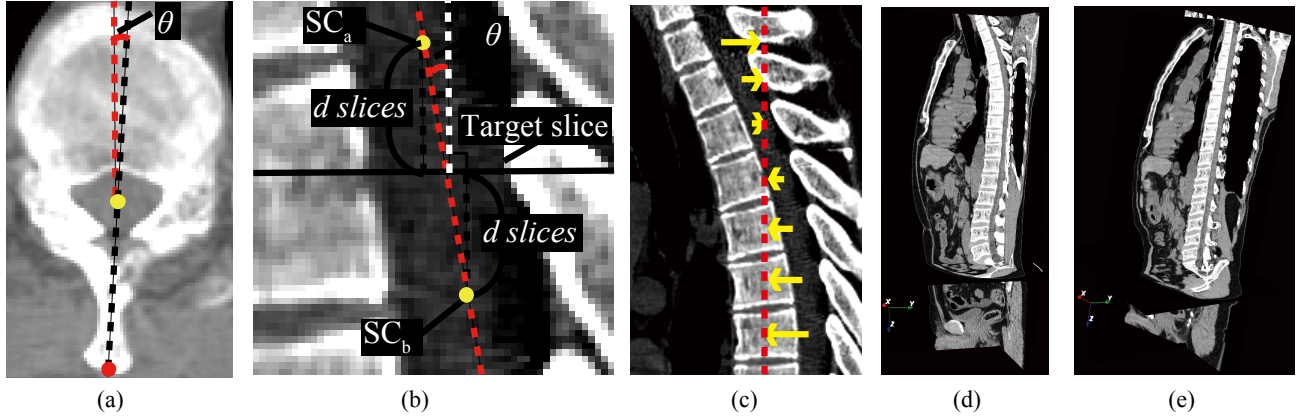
CT images re-formation based on the spinal canal and spinous processes. (a) An axial section view of the spine. Yellow and red circles denote centroid of the spinal canal and the tip of spinous processes, respectively, and an axial rotation of this section is defined as the angle between the black dashed line via centroid of the spinal canal and the tip of spinous processes and red dashed line that indicates vertical line. (b) A sagittal section view of the spine.  $SC_a$  and  $SC_b$  denote centroid of the spinal canal on two axial sections. Sagittal rotation at a target slice is defined as the angle between the red dashed line via  $SC_a$  and  $SC_b$  and the white dashed line that indicates vertical line. (c) A sagittal section view of the spine. The translation is performed so that the center line of the spinal canal moves onto the straight line (red dashed line). (d) Section view of CT images. We can see the spinal curvature. (e) Section view of re-formed images. We can see the spine without its rotation and curvature.
